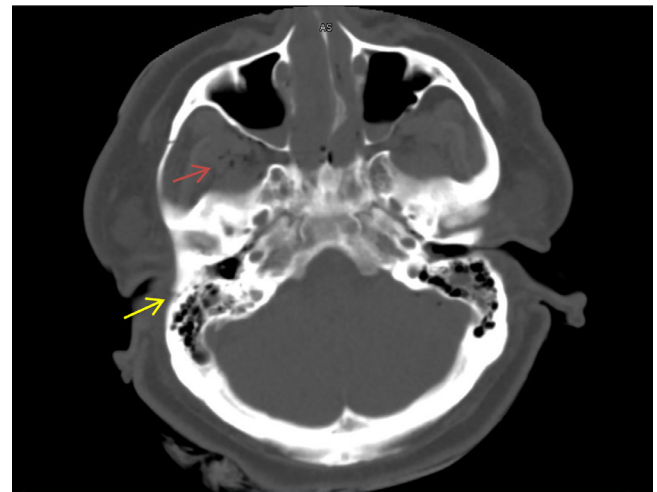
Axial CT head bone window of skull base showing fracture pattern at presentation with presence of air in middle cranial fossa, a common finding in skull base fractures (red arrow), and acute infero-temporal fracture (yellow arrow).
